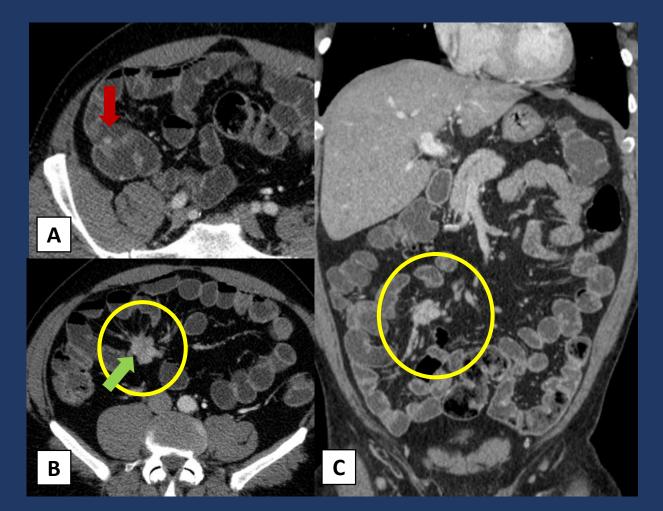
Axial (A, B) and coronal (C) CT enterography shows a small hyperenhancing polyp (red arrow) and a mesenteric mass (circle) with small foci of calcification (green arrow) within it and the surrounding desmoplastic reaction.
